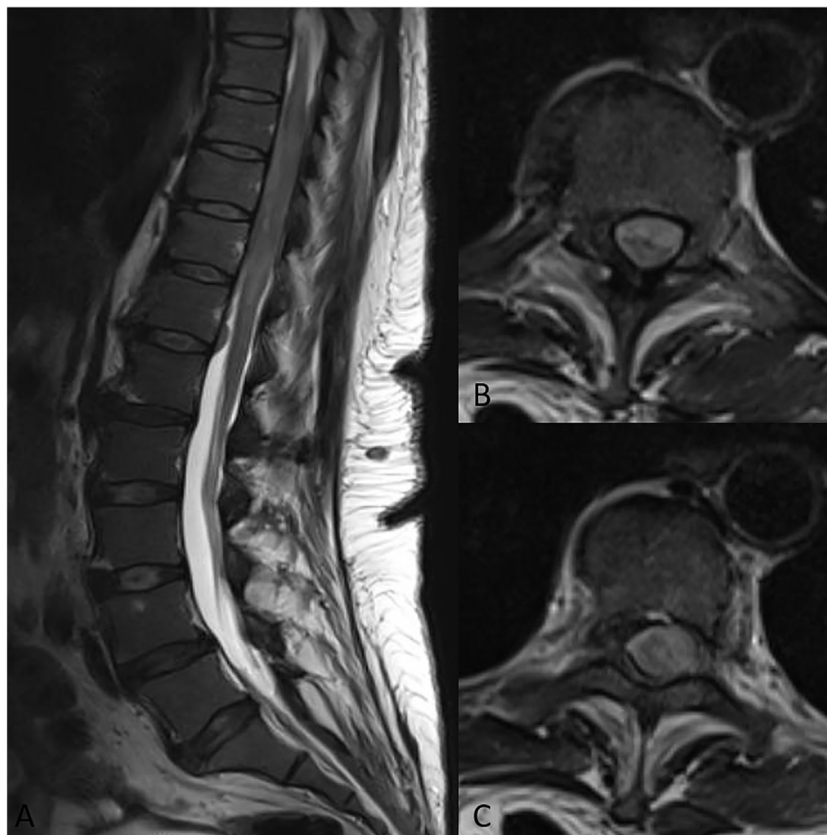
T1 weighted MR imaging with gadolinium contrast. (A) Sagittal and (B and C) axial imaging reveal a homogenously enhancing intradural extramedullary lesion causing severe cord compression at T10 and T11.
